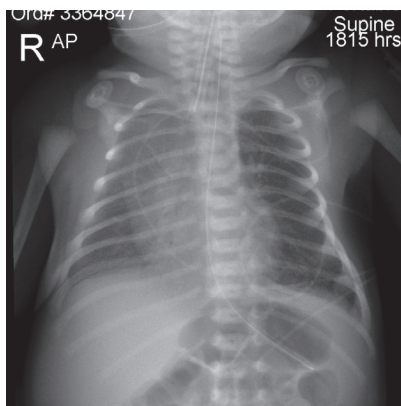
Chest X-ray after 1 dose of surfactant and two needle decompressions.
